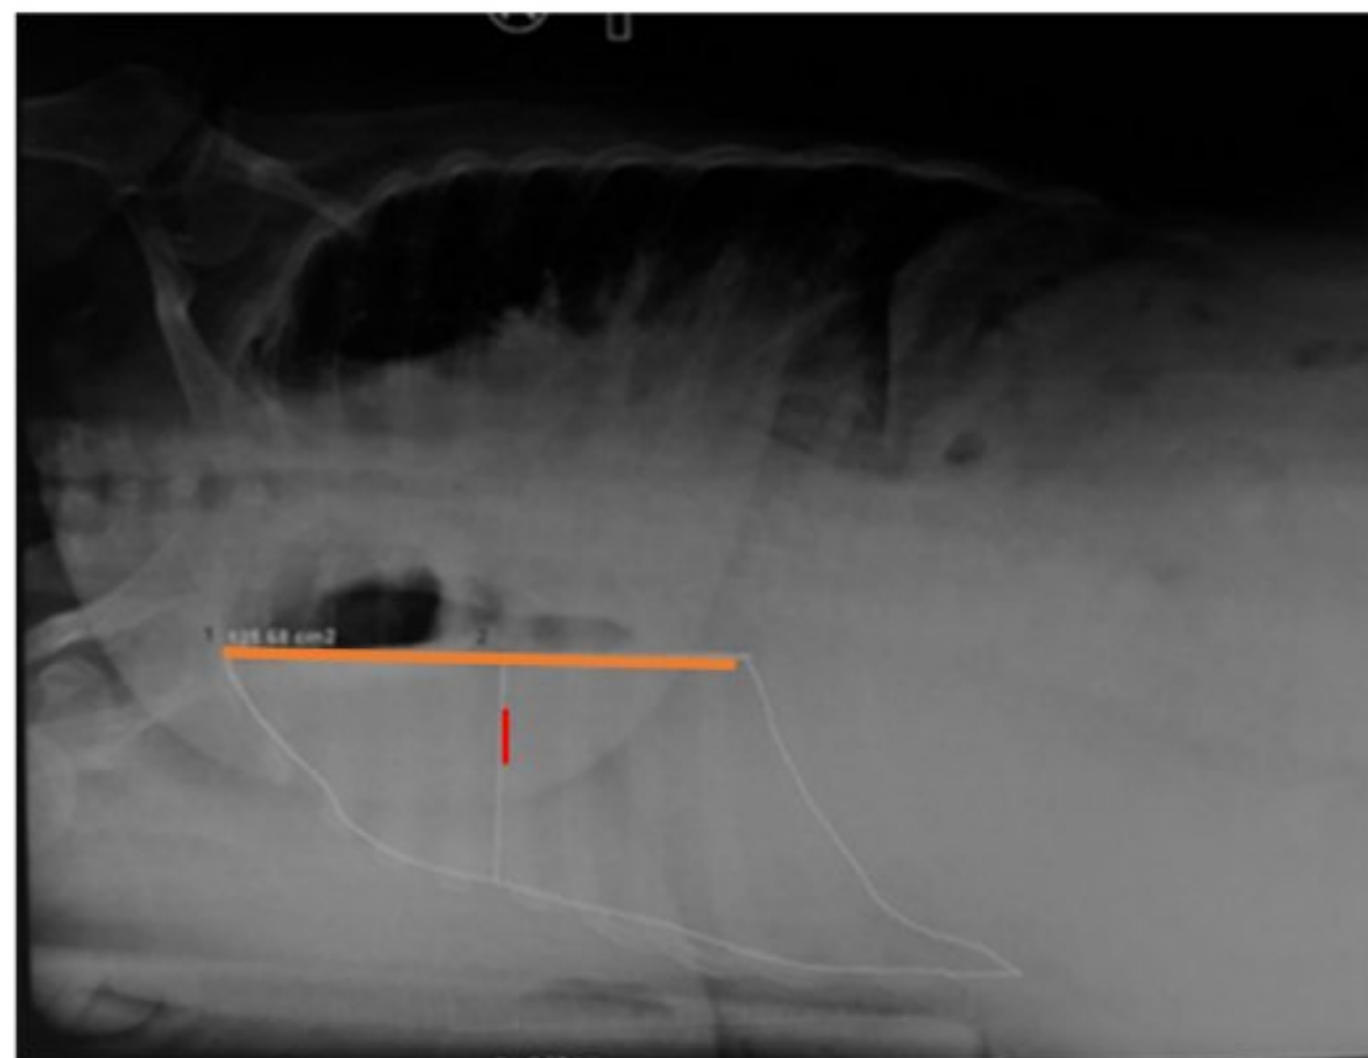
Length measurement of image of pleural effusion (l) of lateral decubitus position of chest x-ray.
